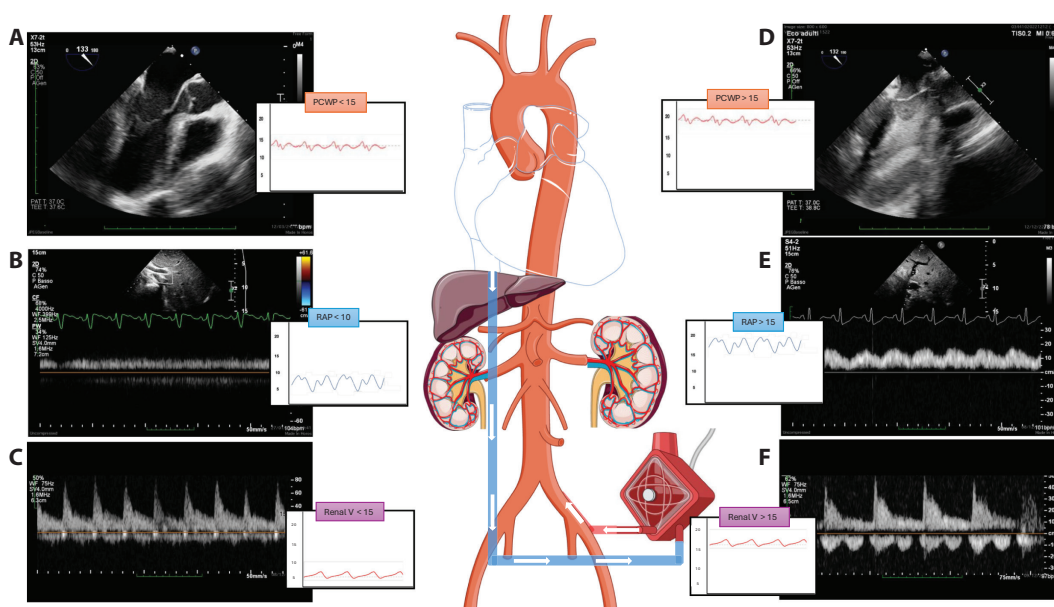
Side by side comparison of two AMI related CS on V-A ECMO with a non-congestive physiology on the left characterized by unloaded LV with normal aortic valve opening at each heart-beat and low pulmonary capillary wedge pressure (PCWP - A); continuous portal vein pulsatility corresponding to effective offloading of RV and lower right atrial pressure (RAP - B) and continuous renal venous flow pattern and good kidney perfusion (renal venous pressure < 15 mmHg- Renal Doppler Resistive Index < 0.7 - C). At the opposite, on the right side the case of severe LV dysfunction with overloaded LV and stasis at ventricular and aortic level (PCWP > 20 mmHg); high (>50%) portal pulsatility index with high RAP and congested renal flow (biphasic) with high renal venous pressure (> 15 mmHg) leading to impair perfusion of the renal artery despite the continuous V-A ECMO flow (RDRi > 0.7).
